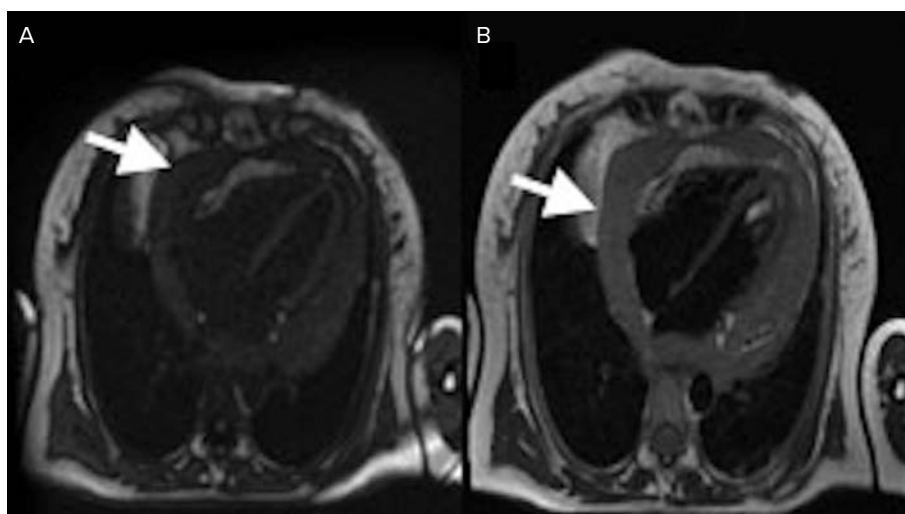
Native cardiac MRI, T1 acquisition (A) and T2 acquisition (B). White arrows indicate tissue-like pericardial thickening with an associated thin liquid component.
